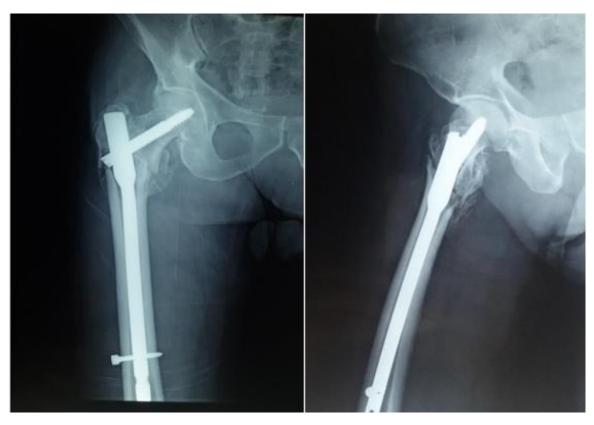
Follow up x-rays: after 5 months
